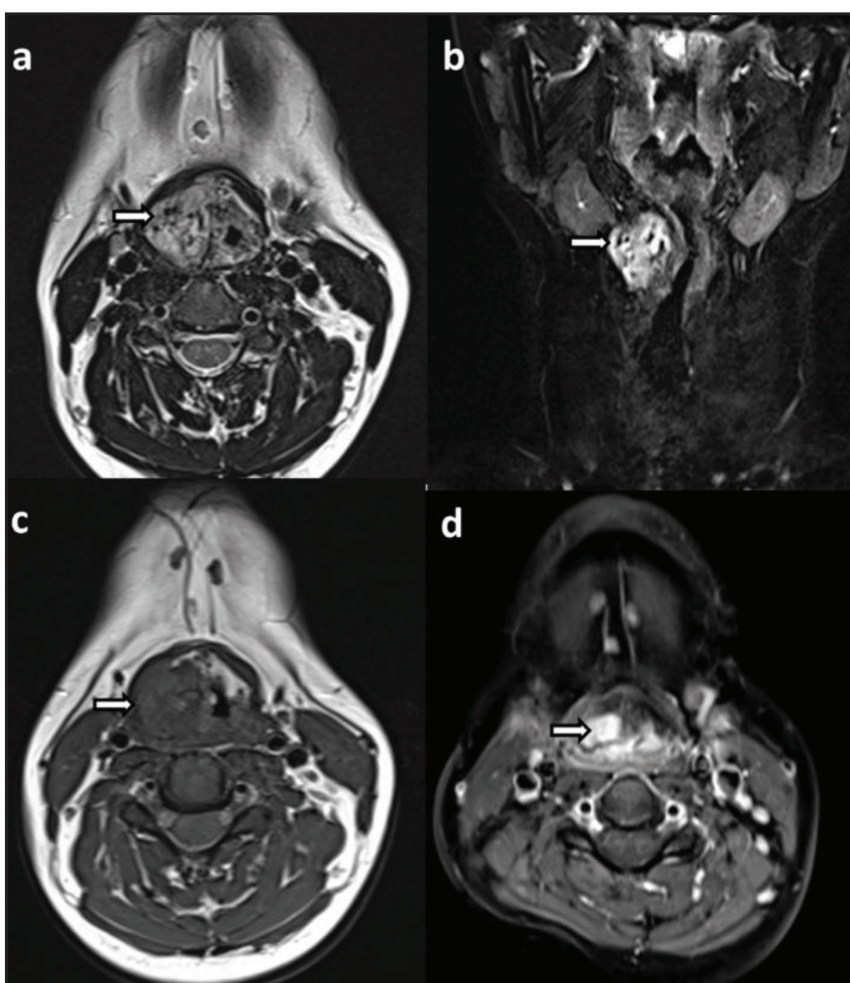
26-year-old female with laryngeal paraganglioma. Contrast-enhanced MRI of the neck, axial T2WI (a), coronal T2-STIR (b), demonstrating a well-circumscribed, lobulated T2/STIR hyperintense lesion (long arrows) with multiple T2 hypointense flow voids centered within the right paraglottic space. The lesion is isointense on T1WI (c) and extends to the laryngeal surface of the epiglottis, narrowing the airway. It shows intense post-contrast enhancement (d).
